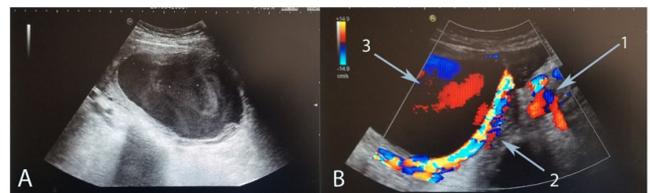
(A) Ultrasound image shows vascular formation with a diameter of 95 mm located in the myometrium. (B) Color Doppler: 1. Dilatation of the afferent and efferent vessels; 2. Parietal rapid blood flow from a large afferent; 3. Turbulent blood flow in the aneurysm cavity.
